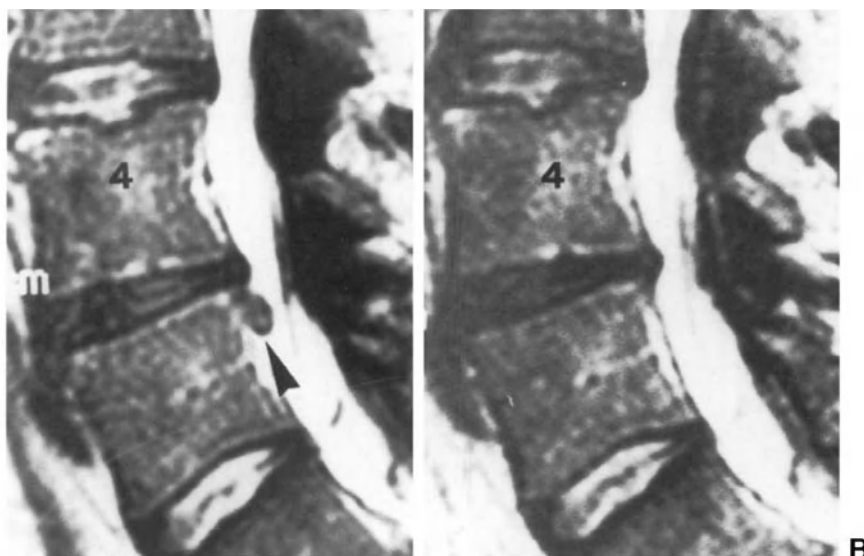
T1-weighted spin-echo right paramedian MR images. (A) Small disc fragment migrated distally to the L4-L5 disc (arrowhead) in a patient with a right lumboradicular syndrome. (B) On MRI performed 8 months after the previous examination, the migrated disc fragment is no longer visible; the patient had undergone conservative treatment with complete resolution of radicular symptoms.
